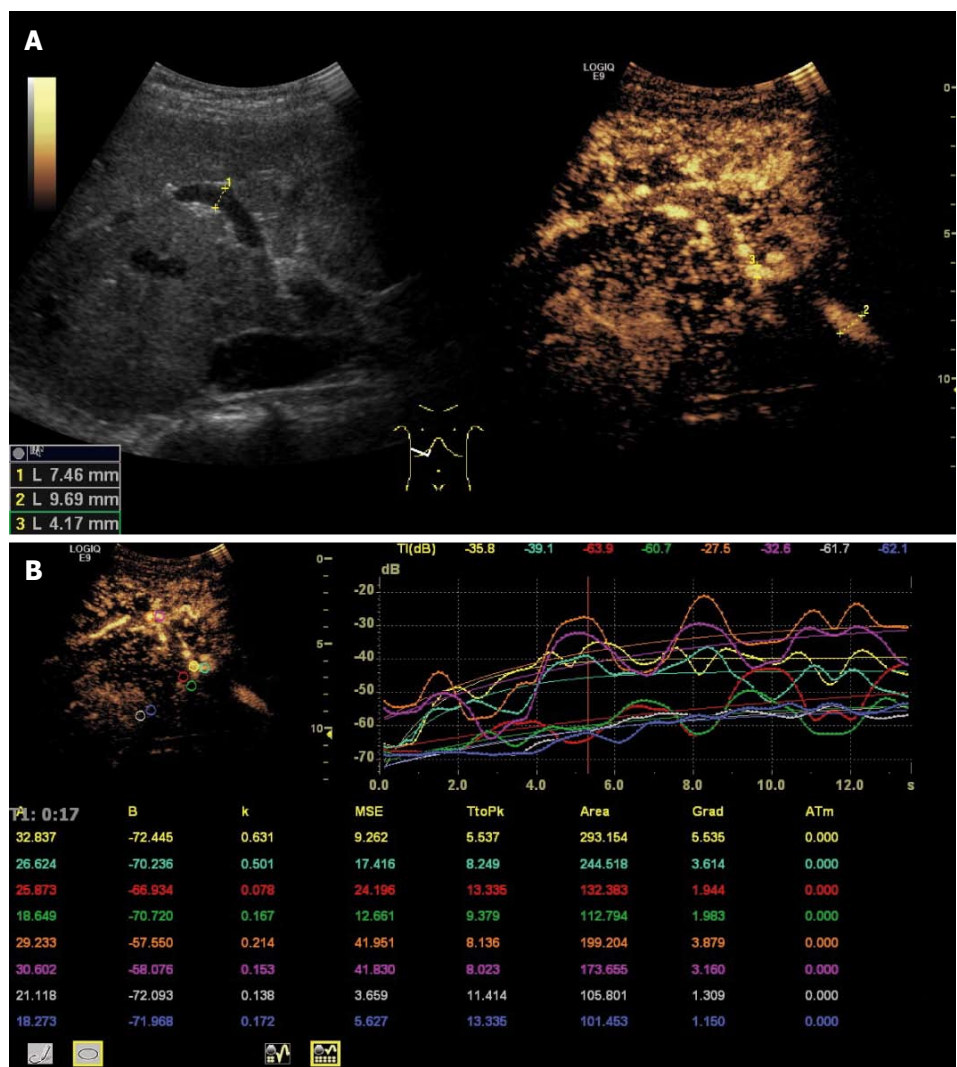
Arteriovenous hepatic malformation (shunt) in a 36-year-old woman. Contrast-enhanced ultrasound image and time intensity curve (TIC) analysis. A: Intrahepatic tortuous hepatic artery in segment IV (central) and VIII of the liver being evident by early hyperenhancement during the arterial phase after injection of 2.0 mL contrast agent. Enhanced mean diameter of the extrahepatic hepatic artery (9.7 mm) without dilation intrahepatic (4.2 mm) and of the portal vein (7.5 mm); B: For TIC analysis eight regions of interest (ROIs) with a diameter of 5 mm were placed in the perfused hepatic artery (yellow, turquoise), portal vein (red, green), shunt region (orange, purple) and hepatic parenchyma (white, blue), two ROIs per region. TIC analysis showed significant lowest time to peak (TTP) and highest area under the curve (AUC) in the hepatic artery and highest TTP and lowest AUC in the portal vein and hepatic parenchyma. Appropriate to the idea that the shunt region represents mixed arteriovenous perfusion, TTP and AUC values were between those of hepatic artery and portal vein. (Caselitz-Kriteria: 1 Major + 2 Minor; Buscarini grade 1; no color spots in peripheral regions).
